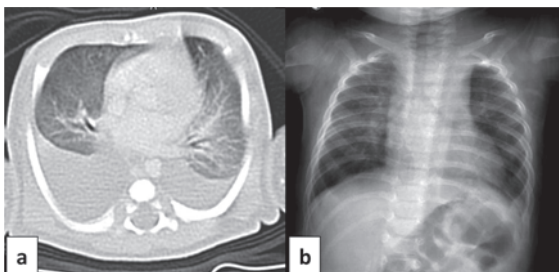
a) Thorax computed tomography demonstrating bilateral pleural effusion. b) Chest X-ray in addition to ultrasonography performed weekly on follow-up revealed pleural effusion to have been completely resolved by the 160th postnatal day.
